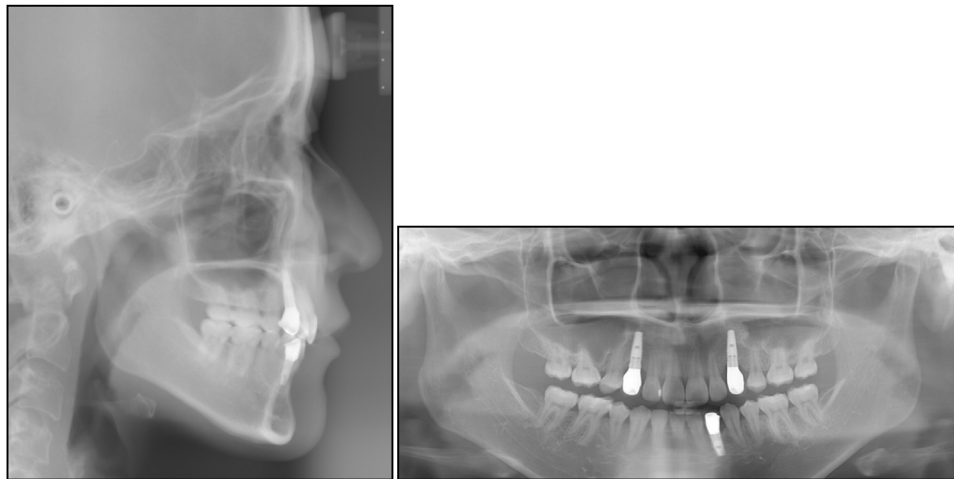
Lateral cephalogram and panoramic radiograph at 3 years postretention.
